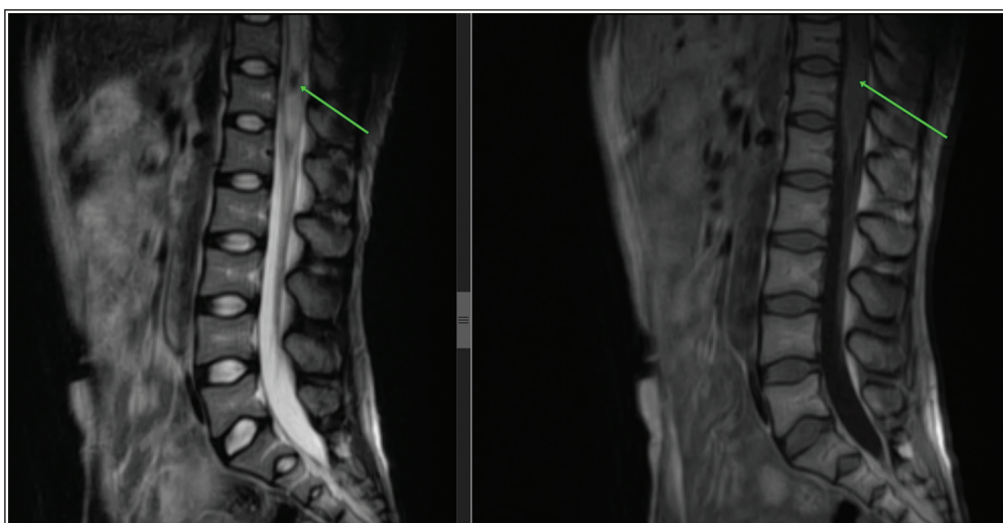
Non contrast, T2 and T1 magnetic resonance imaging of the thoracolumbar spine; showing a hypo-intense lesion straddle between T12 and L1, with surrounding oedema on a mid-sagittal TW2 magnetic resonance imaging, while iso-intense fusiform dilatation of the conus is seen on TW1 magnetic resonance imaging (green arrows)
